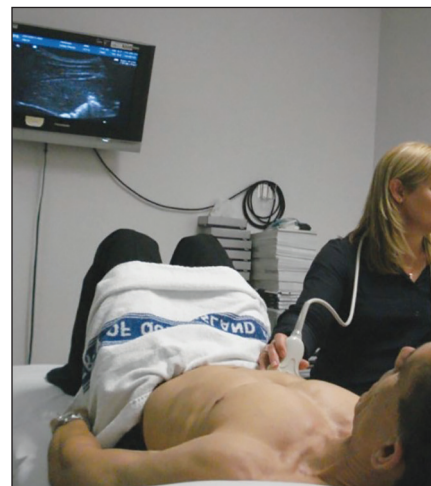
Ultrasound imaging can be used for detailed assessment and biofeedback of contraction of the deep trunk muscles, including the transversus abdominis and multifidus.
